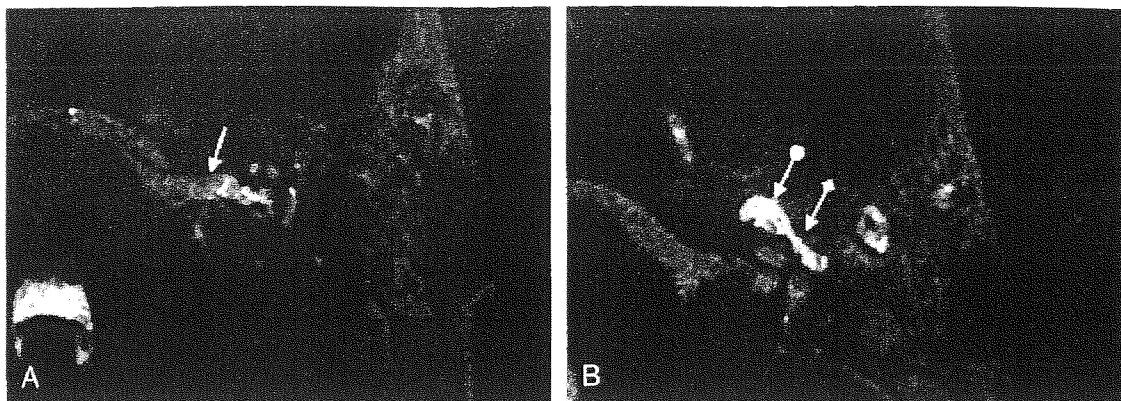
A, B, Preoperative T2-weighted axial magnetic resonance constructive interference in steady-state three-dimensional image, without contrast: cerebrospinal fluid in the enlarged facial canal in the fundus of the IAC (white arrow), geniculate ganglion (arrow round dot), and tympanic portion of the fallopian canal (arrow diamond dot).
